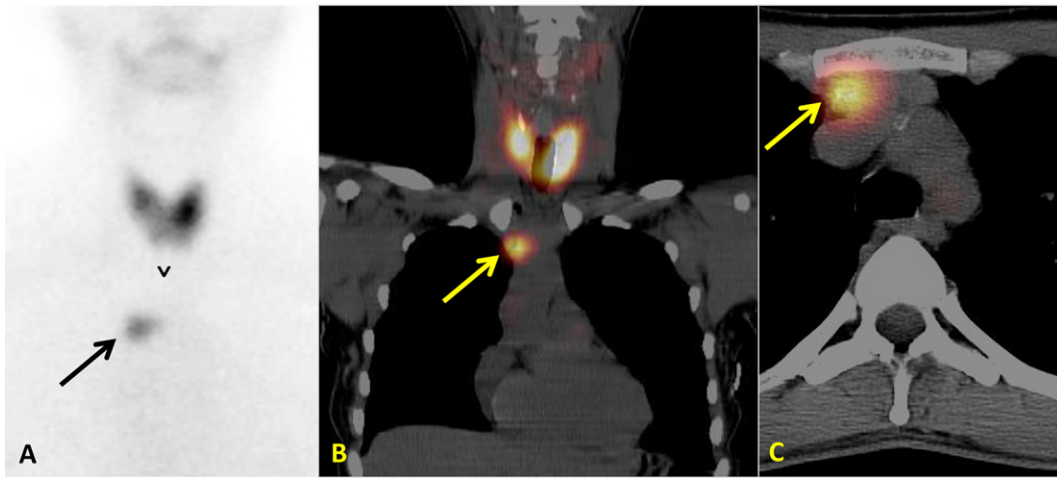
^{99m}Tc -pertechnetate planar (A) and SPECT/CT (B, coronal; C, axial) presentation of a substernal ectopic thyroid tissue (arrow).
